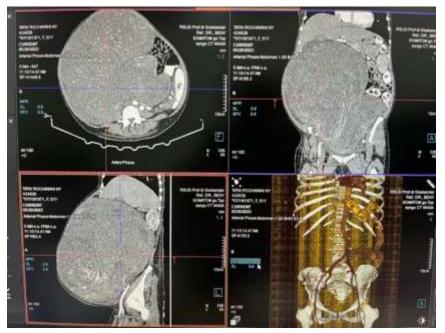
Abdominal Computed Tomography Scan with contrast revealed a giant myoma uterine which has feeding from the uterine artery bilateral and minimal ascites.
